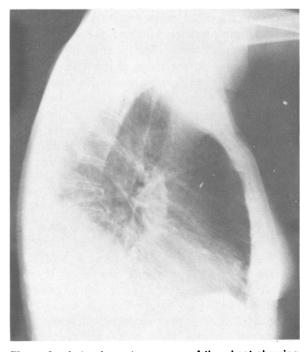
Lateral roentgenogram of the chest showing right lower lobe infiltrate.
